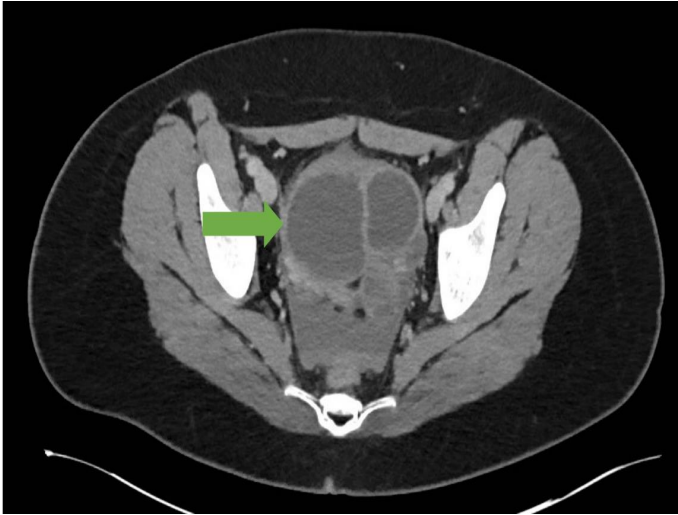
Preoperative Computed Tomography Showing Multiloculated Pelvic Cyst (Green Arrow)
